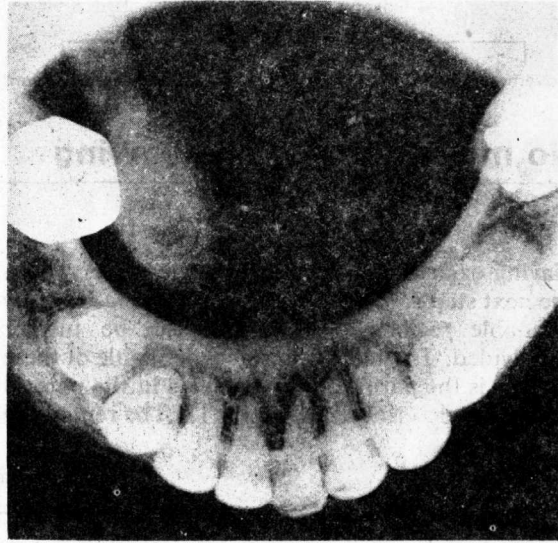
Plain x-ray of the floor of the mouth, showing a large submandibular calculus lying in the submandibular duct near its termination. It would appear likely that the distal oval structure was the primary calculus which, by obstructing the duct, favoured the formation of the tail of secondary calculus which extends proximally.
